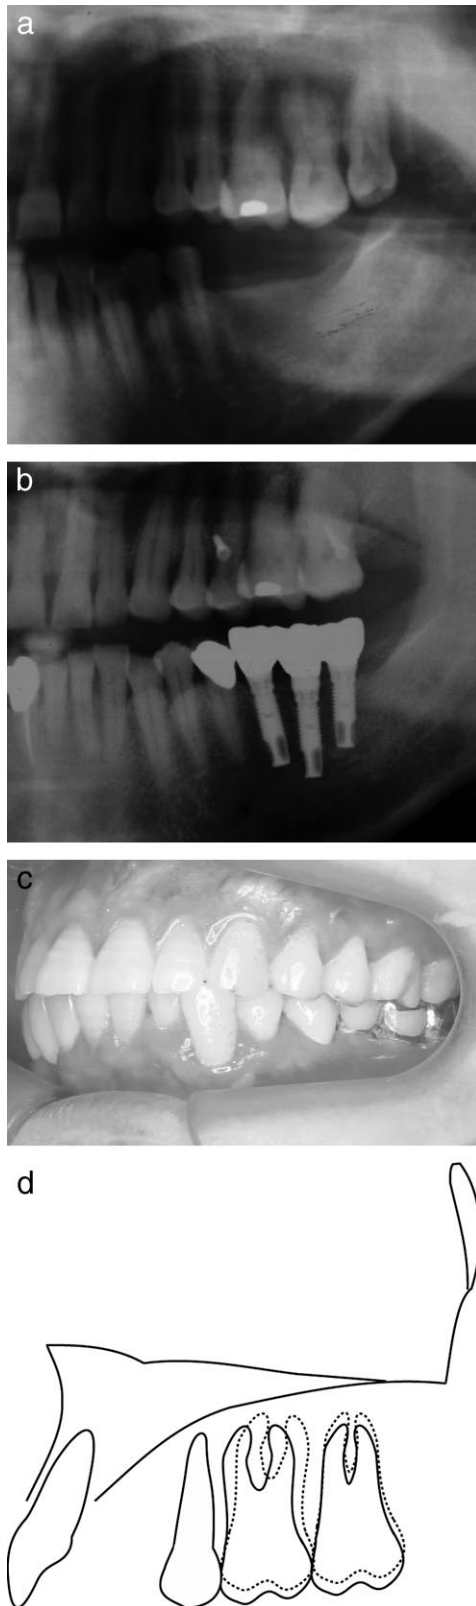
(a, b) Initial and posttreatment radiograph. (c) Final intraoral slide. (d) Superimposition of initial (solid line) and final (broken line) tracings.
